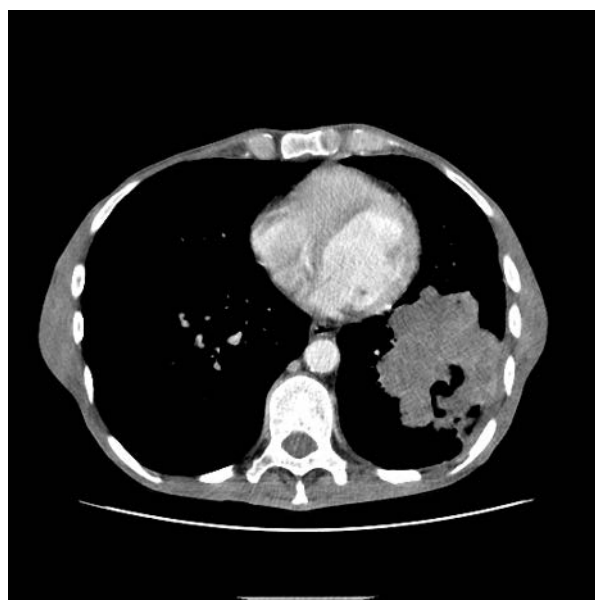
Chest CT. A large oval irregular mass in the lower left lobe with the contrast enhancement
